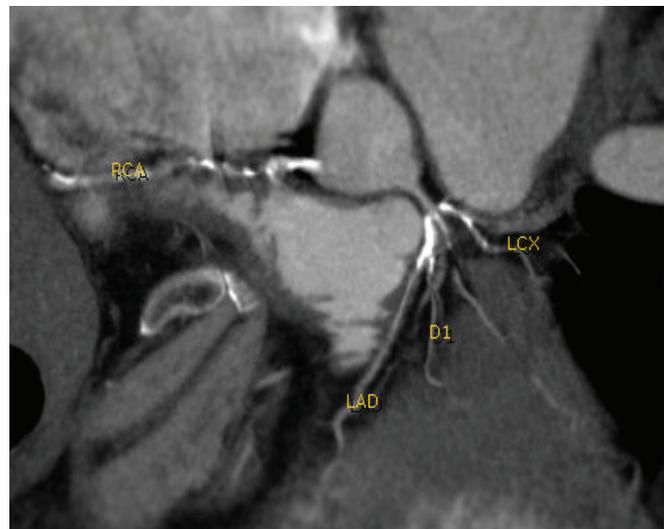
CT scan of the heart showing extensive coronary calcifications
